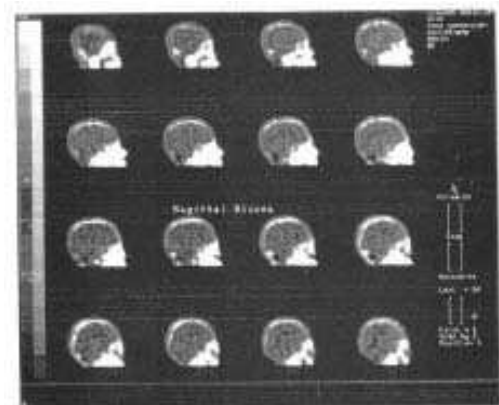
Patient no. (10): Follow up after 6 months SPECT scanning showed global hypo perfusion of cerebral cortex and cerebellum. No focal perfusion defect (sagittal view).
